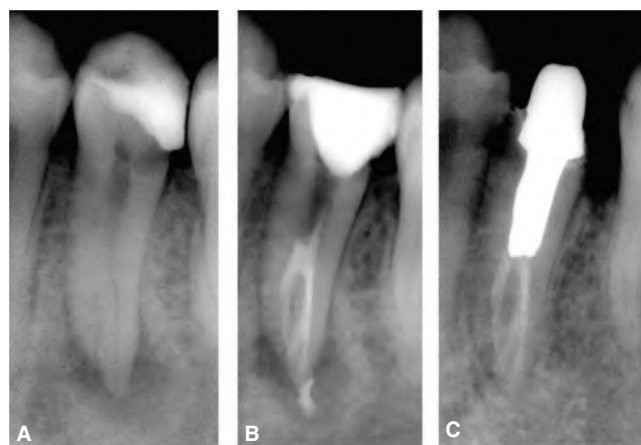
Endodontic treatment in a symptomatic mandibular premolar with complex radicular anatomy. A. Preoperative radiograph showing periapical radiolucency associated with necrotic pulp. B. Immediate postoperative radiograph showing endodontic filling of a trifurcated root canal system. C. 3-year follow-up radiograph showing resolution of the periapical radiolucency.
